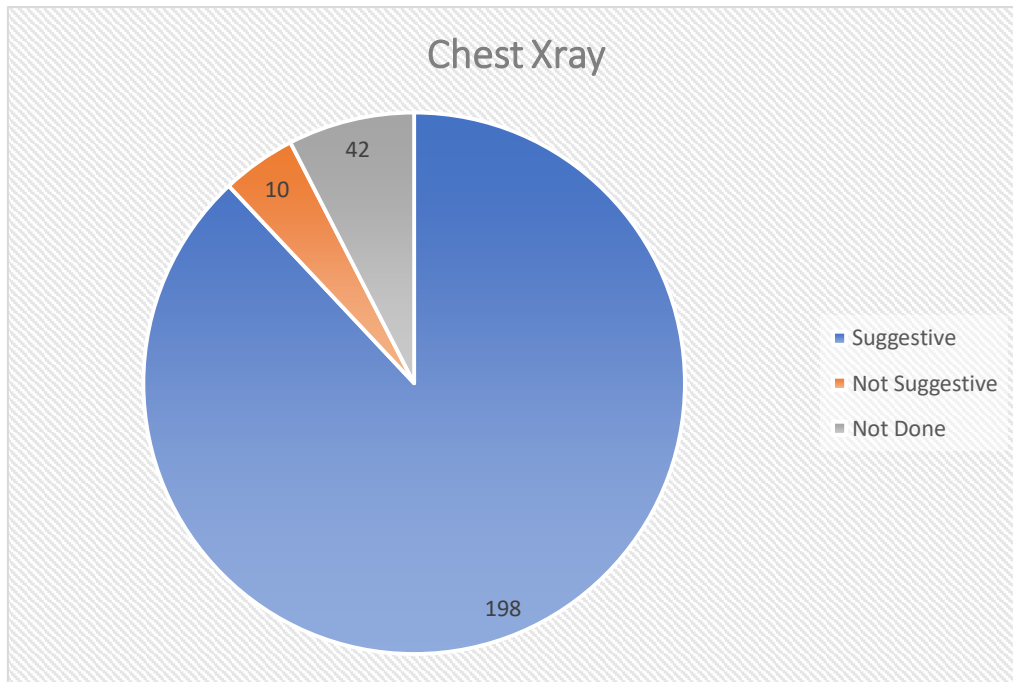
Chest Xray of Participants
